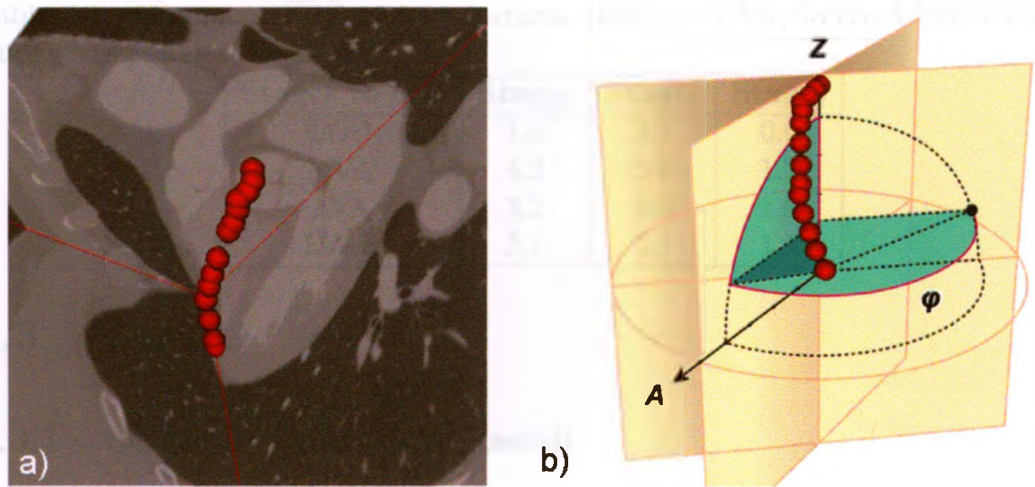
(a) LAD extracted from patients CT data (b) LAD with the axes of rotation.
